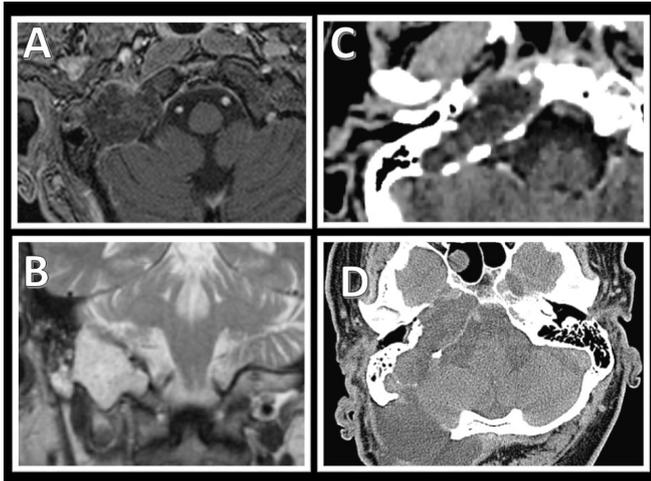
Pre-operative images of the lesion (MRI and CT).
